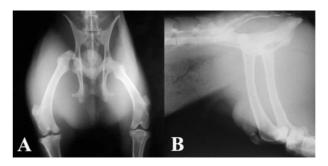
(A) Cranial-caudal and (B) lateral radiograph view of the right coxofemoral joint of a water deer.
